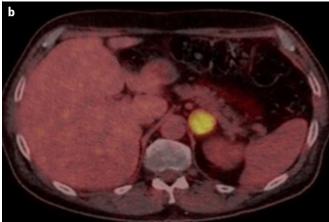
Computed tomography (CT) adrenal protocol (a) and PET scan (b) axial images revealing a 32×30 mm left adrenal lesion with features not typical for an adrenal adenoma including Hounsfield units of 58 and a washout of -62.5% at 15 min. FDG PET CT revealing an intensely FDG avid adrenal lesion suggesting malignancy.
